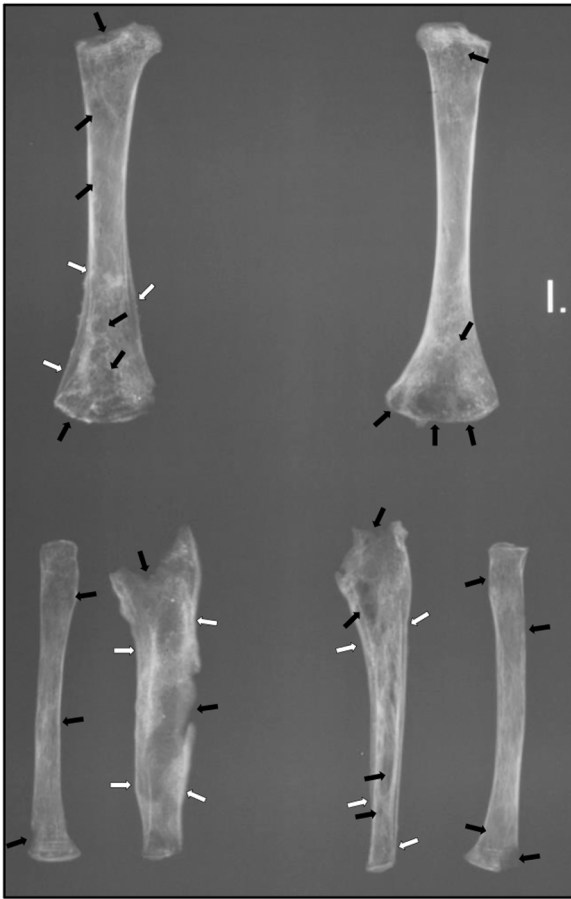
Radiograph of the right and left arm bones of Individual IG-124. The black arrows indicate osteolysis, the white arrows indicate areas of marked cortical thickening.
